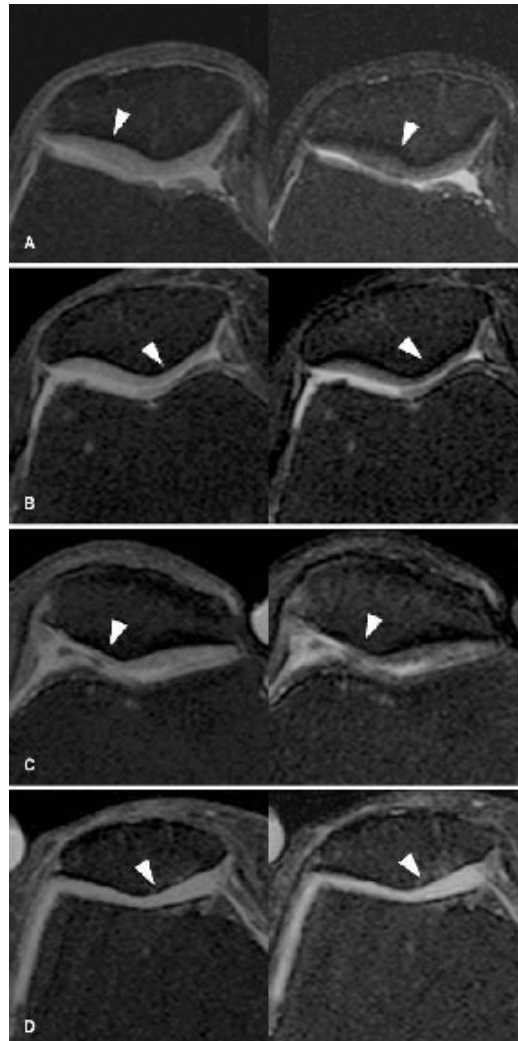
Axial dual turbo spin echo MR images of different grades of cartilage thinning at the patella (arrowheads demonstrate the example area): A grade 0 (normal cartilage); B grade 1; C grade 2; D grade 3 (full thickness)
